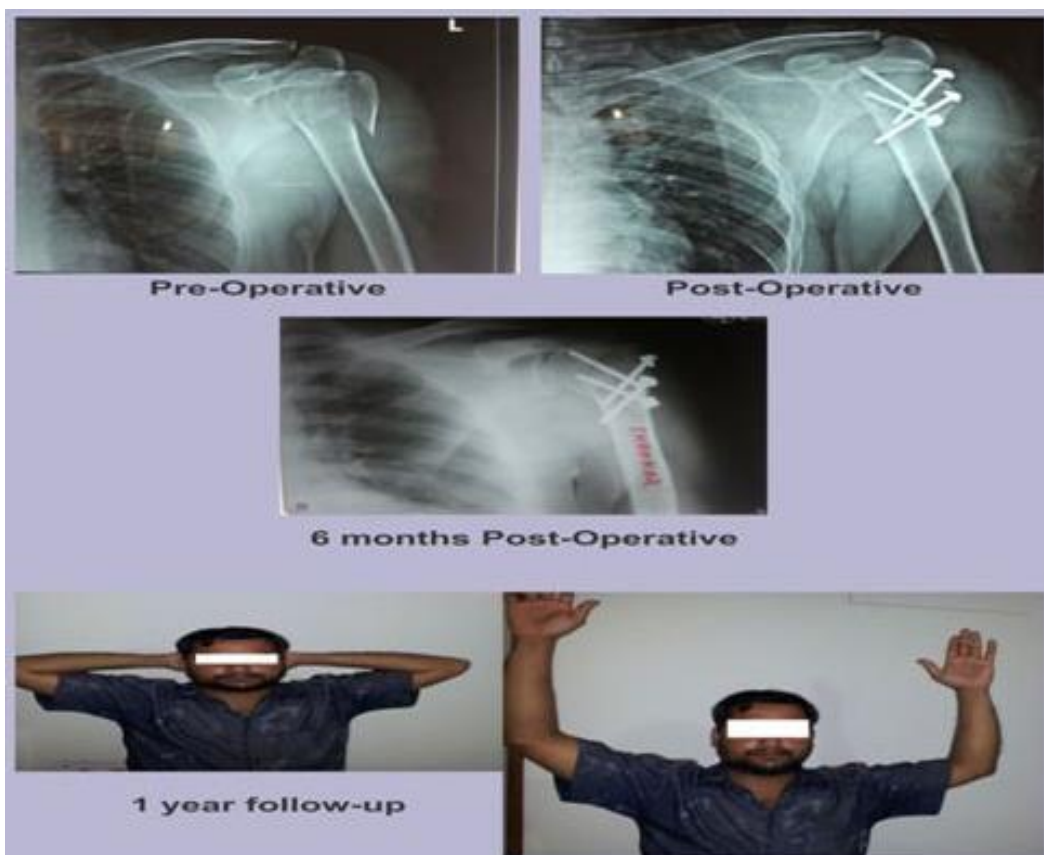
Clinical and X-ray pictures of closed reduction and percutaneous suture fixation.
